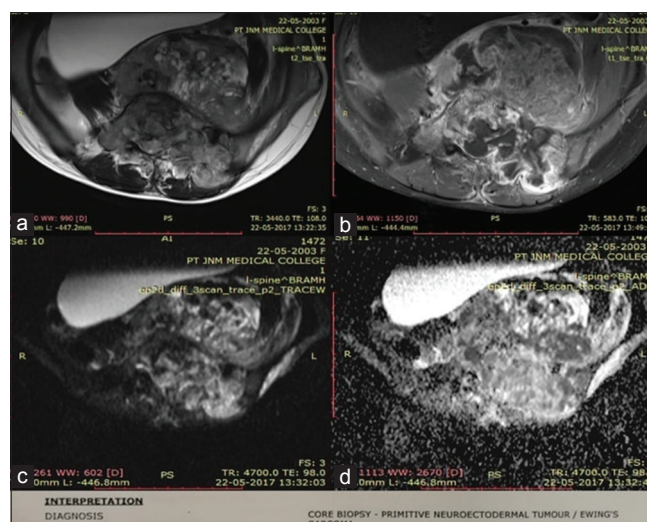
A 14-year-old female presented with a large soft tissue mass over the lower back. (a) Axial T2-weighted imaging (WI) shows heterogeneously hyperintensity of L5 vertebrae with associated large soft tissue component. (b) Axial T1-weighted post-contrast image at the level of L5 vertebrae shows heterogeneously enhancement with the involvement of posterior elements and a large paravertebral soft tissue component. (c) Axial diffusion WI at same level shows diffusion restriction in vertebrae and surrounding soft tissue. (d) Corresponding axial apparent diffusion coefficient (ADC) map ($b = 0$ and 1000 s/mm^2 shows decreased signal intensity with an ADC value of 0.65 in bone and 0.67 in soft tissue component). [Biopsy revealed PNET/Ewing's sarcoma]
